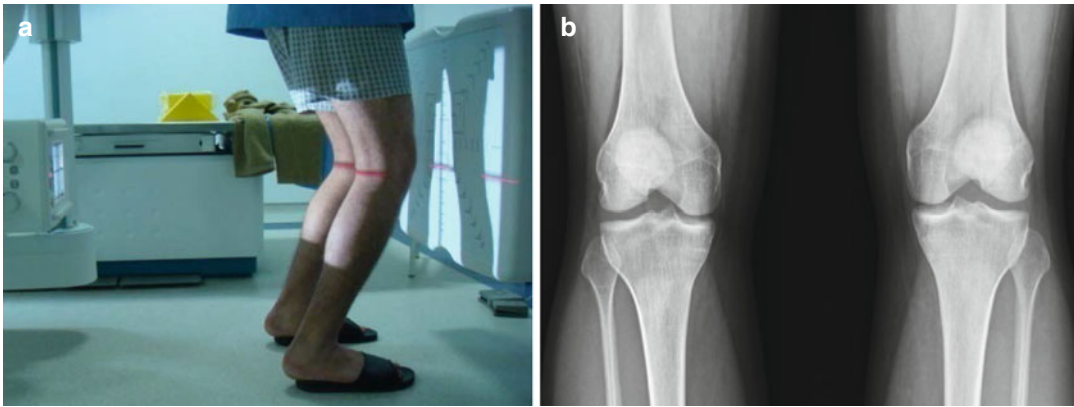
(a) Position of the patient with 15° knee flexion in standing and the x-ray device. (b) Imaging of Rosenberg radiograph
